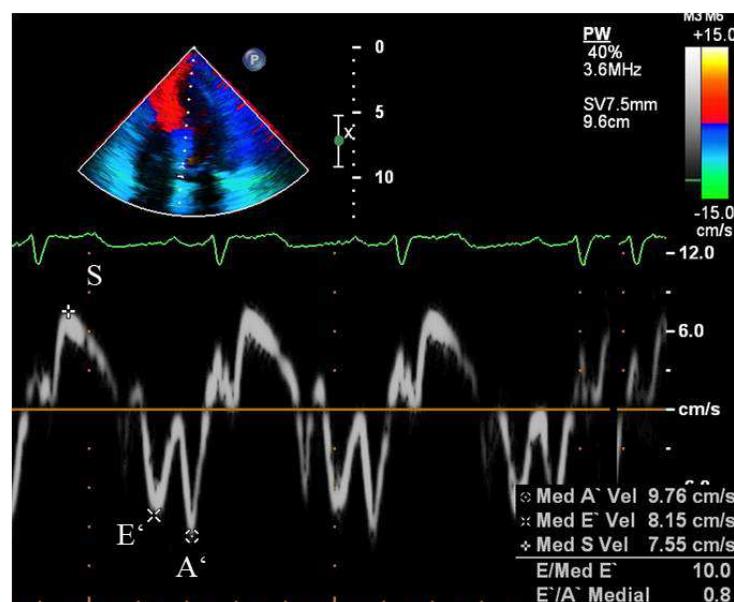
Pulsed Tissue Doppler of the medial mitral annulus. S - systolic velocity above the baseline as a result of annular movement toward the apex, E'm - early diastolic velocity below the baseline due to annular movement away from the apex, A'm - late diastolic velocity, at the time of atrial contraction.
